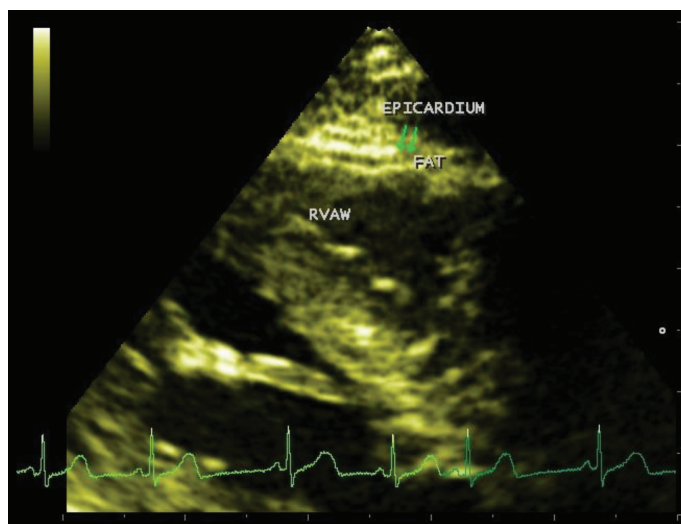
Echocardiographic imaging of the epicardial fat
